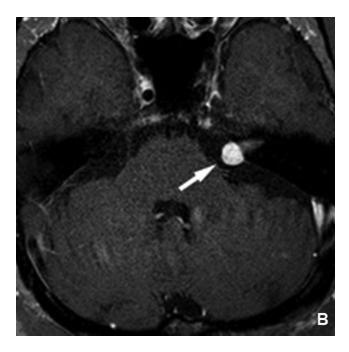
71-year-old man with asymmetric sensorineural hearing loss. Serial followup contrast-enhanced, T1-weighted, fatsuppressed axial MRI sequences obtained after gamma knife radiosurgery. The left-sided vestibular schwannoma (white arrows) shows slight interval enlargement with central nonenhancement of the cisternal component at three months posttreatment (A), consistent with early post-treatment changes expected after stereotactic radiosurgery. Three years after gamma-knife treatment (B), the lesion has not increased in size; the size of the cisternal component is slightly decreased compared to the pretreatment baseline scan (Fig. 1C, above).
